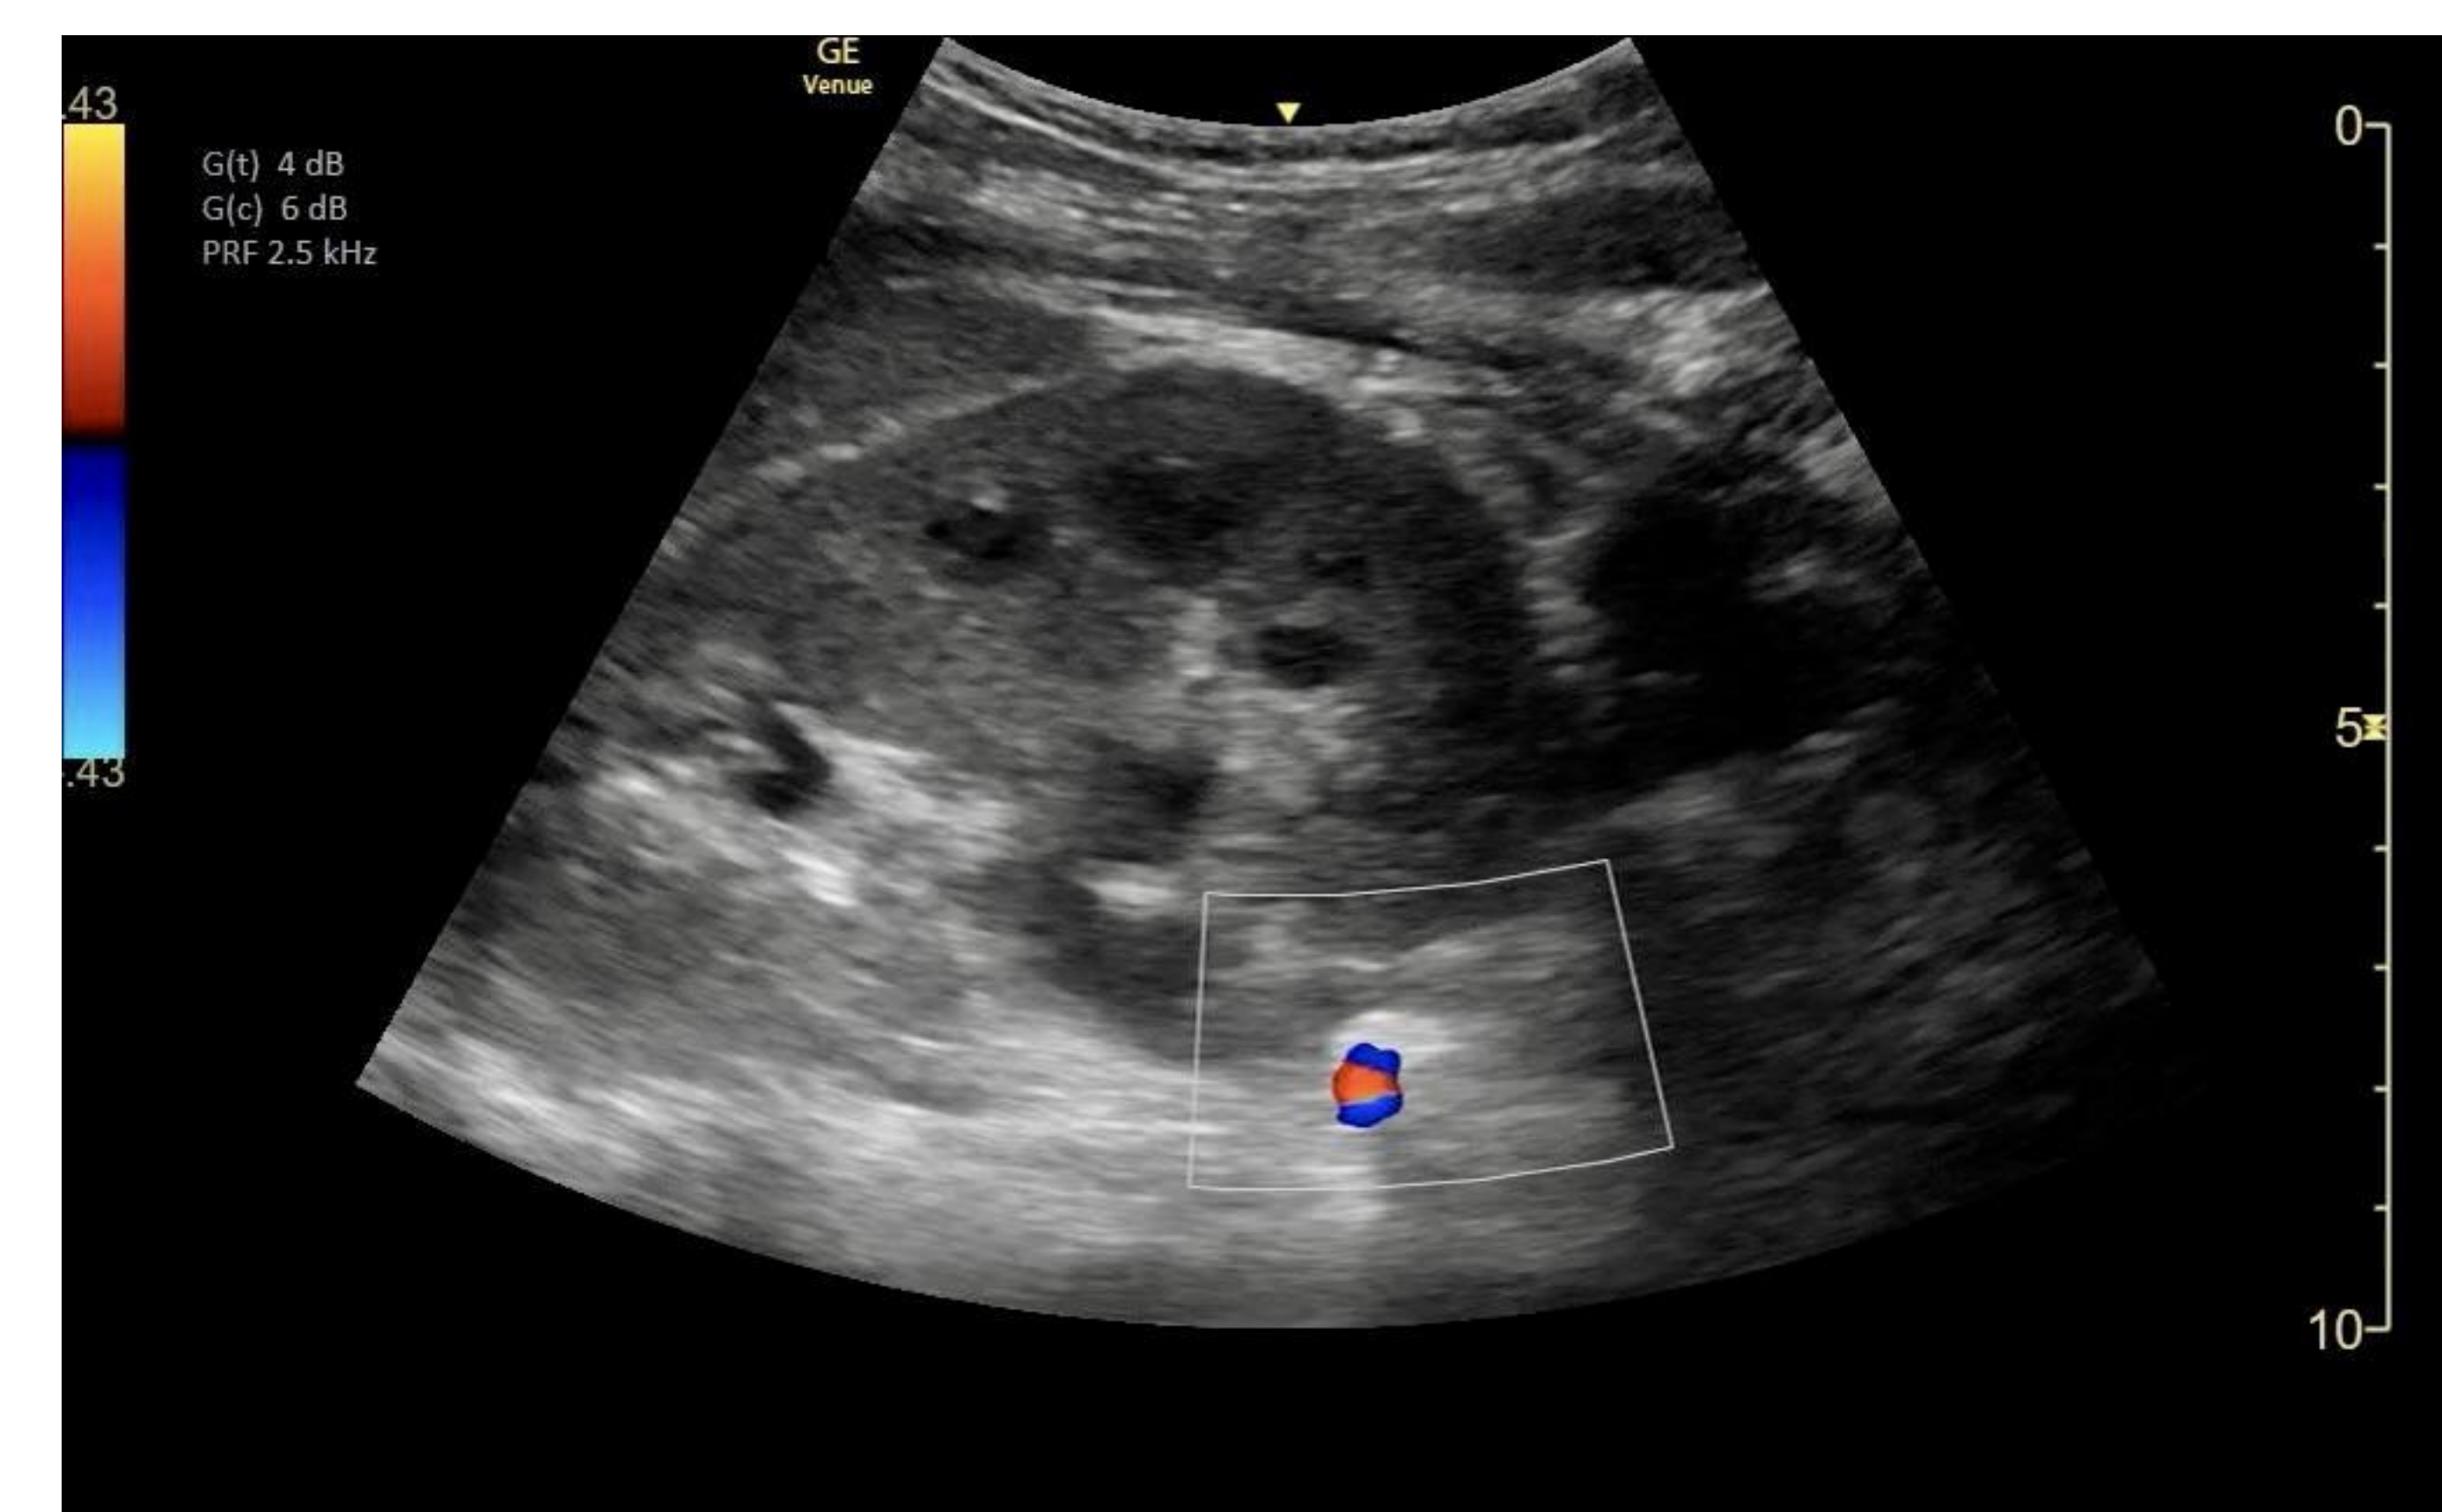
Color flow doppler demonstrates twinkling artifact when placed over the calculus.
